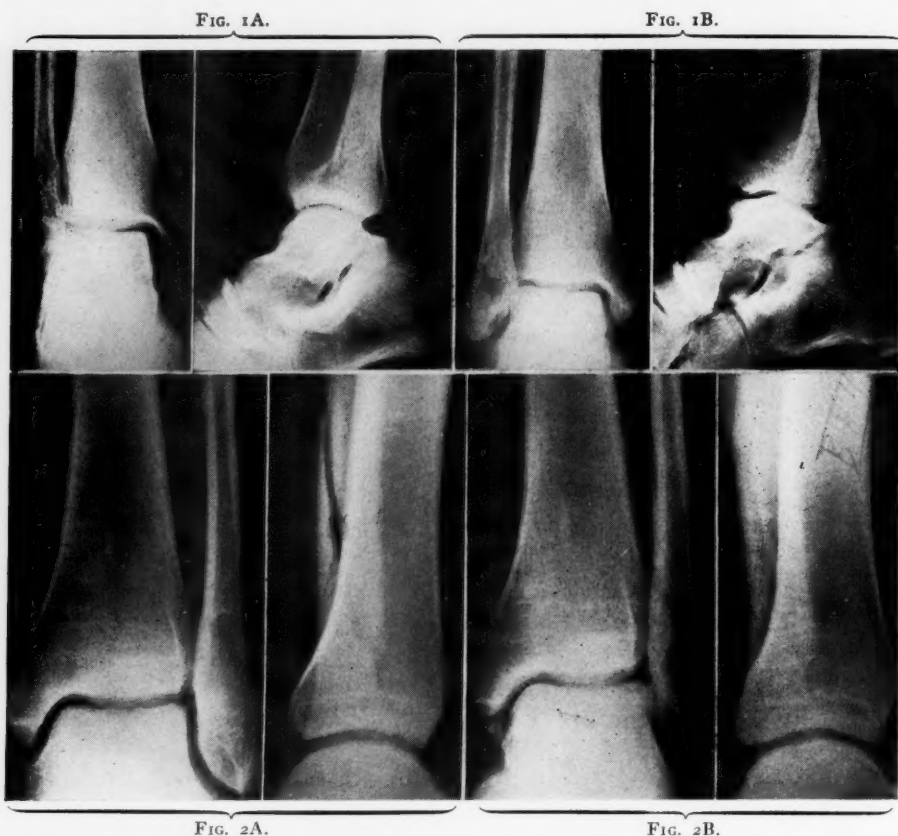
(A) Fracture of lower fibula, January 19, 1940. One injection of procaine; elastic-adhesive bandage; crutches for one week; seventeenth day, no pain or disability. Lost three days work. (B) Follow-up roentgenograms, March 13, 1941.
